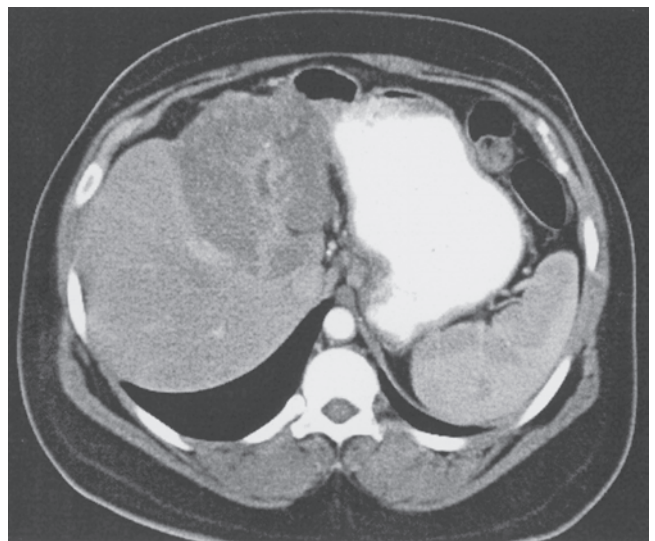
CT scan of intrahepatic cholangiocarcinoma. The image shows an intrahepatic cholangiocarcinoma primarily involving the left lobe of the liver.
